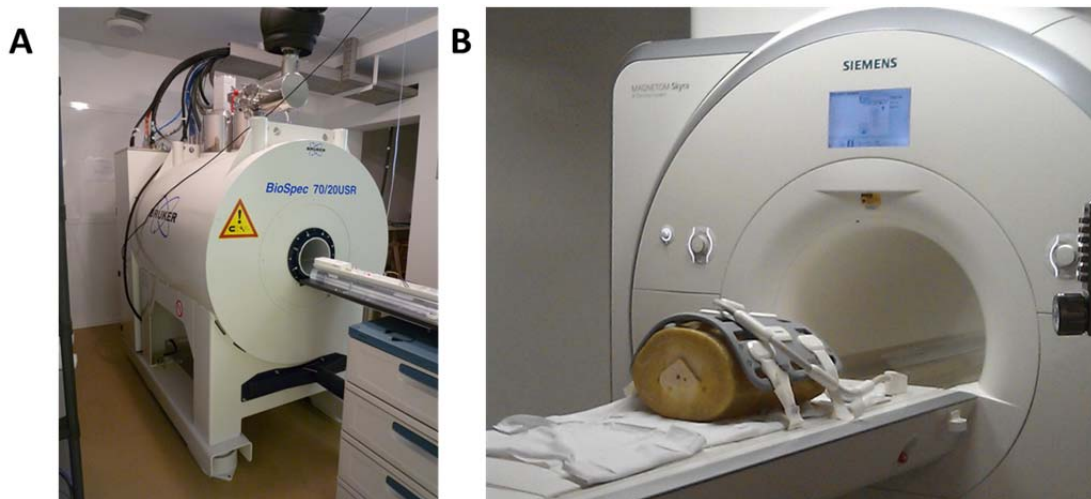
Preclinical and clinical cardiac experimental setup. A) 7 T preclinical MRI scanner, Bruker BioSpec 70/20 USR. B) 3T clinical MRI scanner, Skyra, Siemens Medical.
